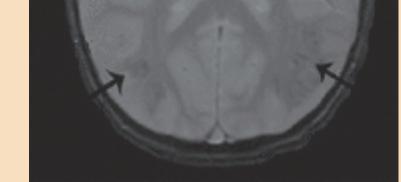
CT (a) and MRI (b) scans demonstrating occipital CCs.
